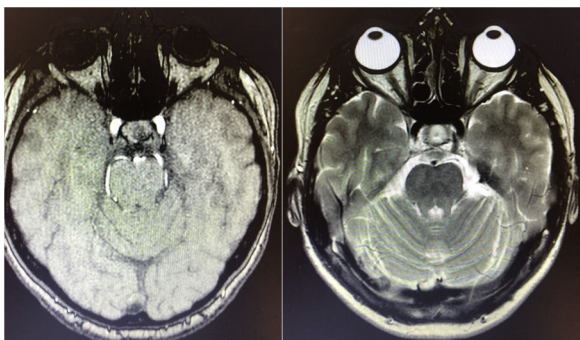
Brain MRI (axial plane). T1-weighted contrast-enhanced (left) and T2-weighted sequences (right) at the level of the pons, revealing no arteriovenous malformations or other structural lesions at the cerebellopontine angle.
